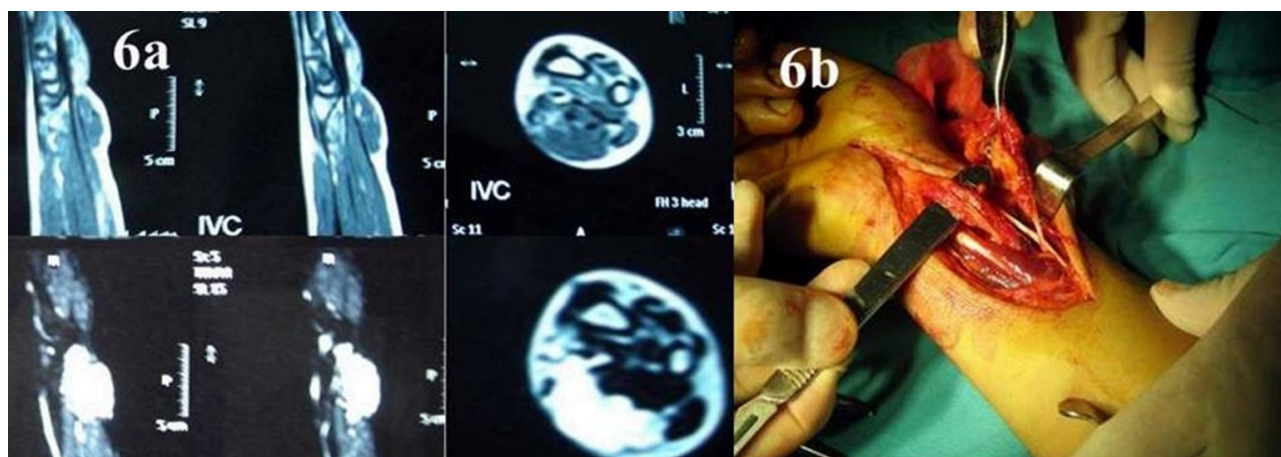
a MRI of hemangioma. Sagittal and axial images demonstrating an 3x3x1.5 cm lesion in the volar side of the wrist. b Macroscopic view of the hemangioma.
